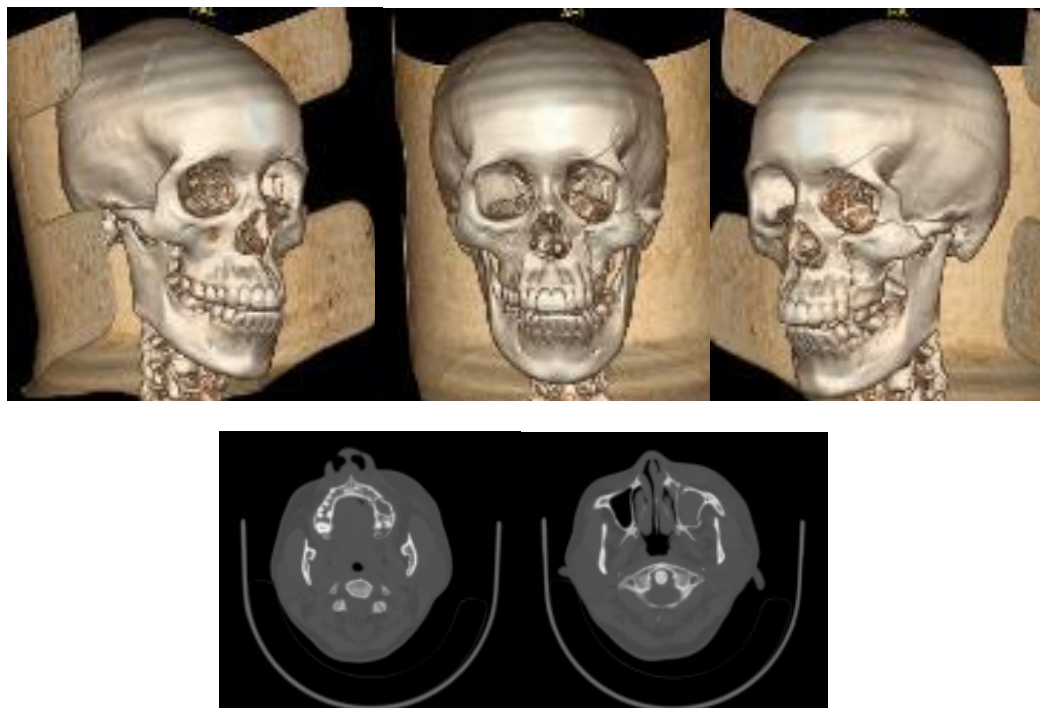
CT scan of the head shows the fracture line of the left maxillary bone, left zygoma, left orbital rim inferior margin, left ethmoid bone, and left frontal bone.
